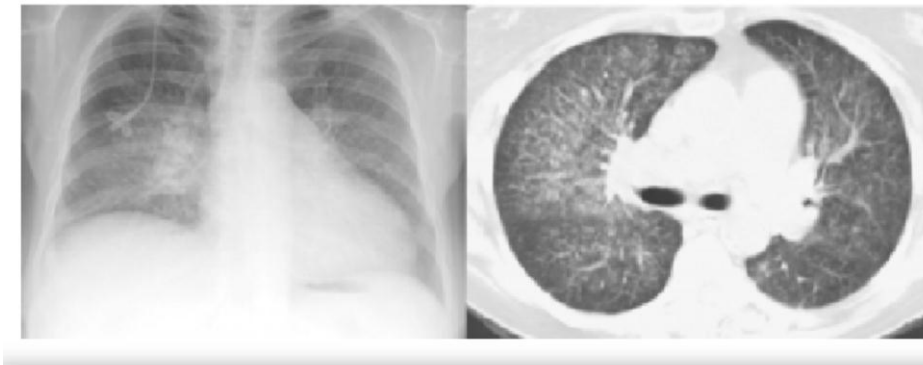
Figure 1: Chest radiograph and CT scan of chest showing bilateral fine nodular infiltrates
